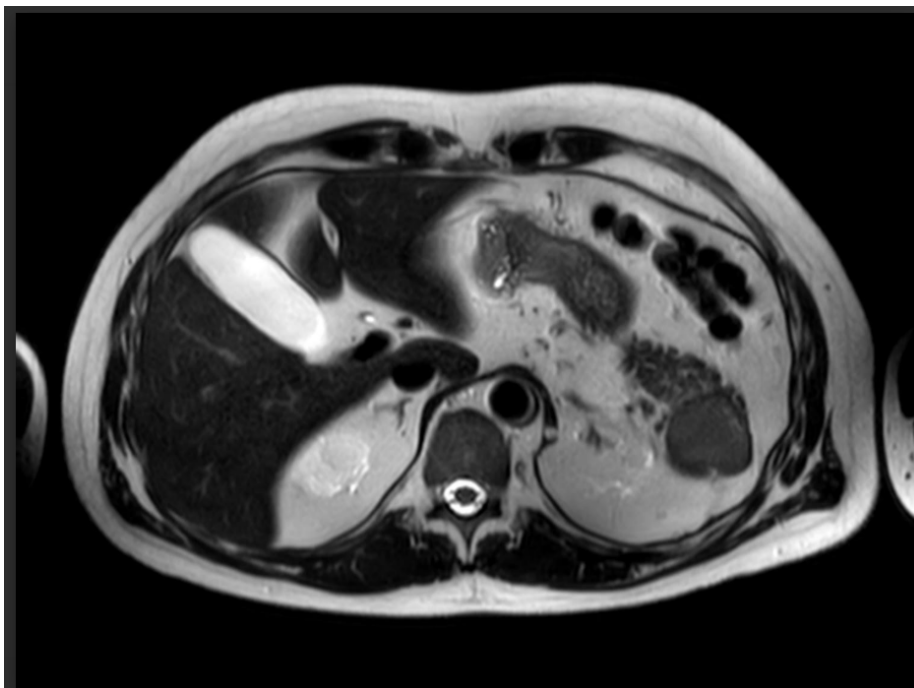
MRI scan from August 2016
